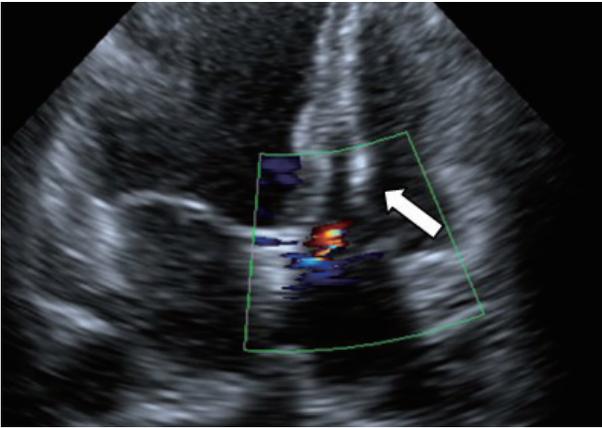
Four chamber view of transthoracic echocardiography shows an echogenic linear structure of cardiac foreign body which was misdiagnosed as moderator band (white arrow).
